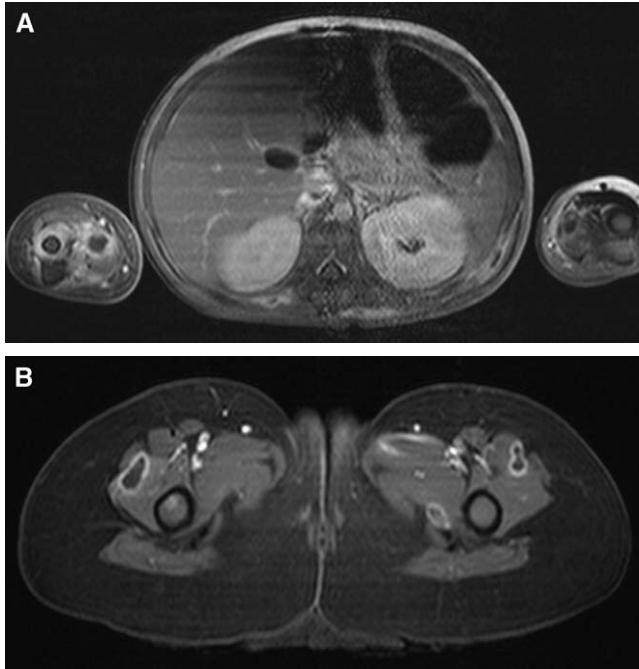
(A and B) MRI of a child with multiple sites of pyomyositis caused by CA-MRSA.
